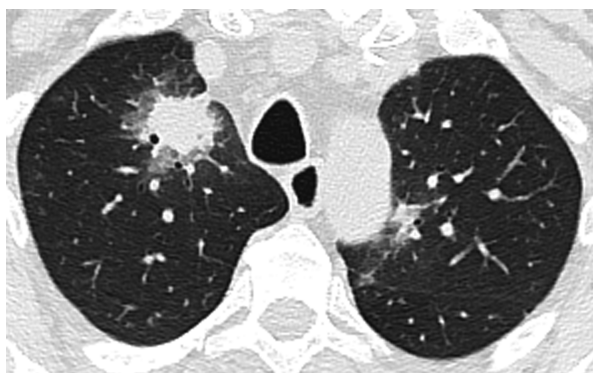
Bilateral invasive aspergillosis in the upper lobes can be seen on chest CT. The larger right-sided infiltrate with its spiculated nodule is surrounded by ground-glass opacity. This 'halo sign' represents fungal vessel invasion.
